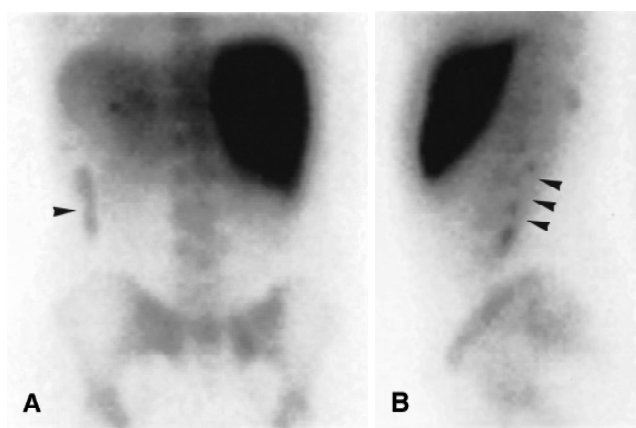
Postoperative denatured blood cell scintigraphy demonstrated four foci of residual splenic tissues (arrow) in a 17-year-old female patient suffering from idiopathic thrombocytopenic purpura. No accessory spleen was detected pre- or intraoperatively. There has been no clinical recurrence at 40 months postoperatively. A Posterior view. B Left lateral view.
